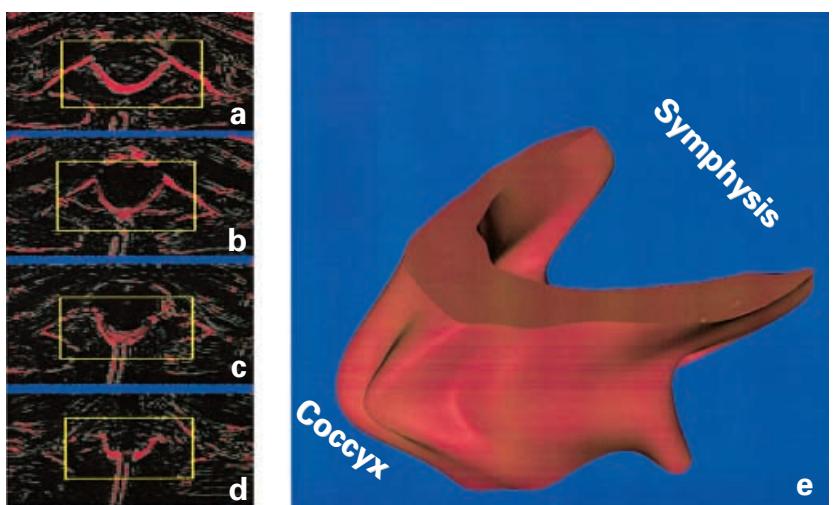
Axial sequential subtracted MR images (a-d) showing the configuration of the pubococcygeus muscle. The 3D reconstruction (e) shows Δ PF-V (axial) and represents the relative displacement produced by the pubococcygeus muscles. Δ PF-V in this plane was measured within the yellow rectangle.
